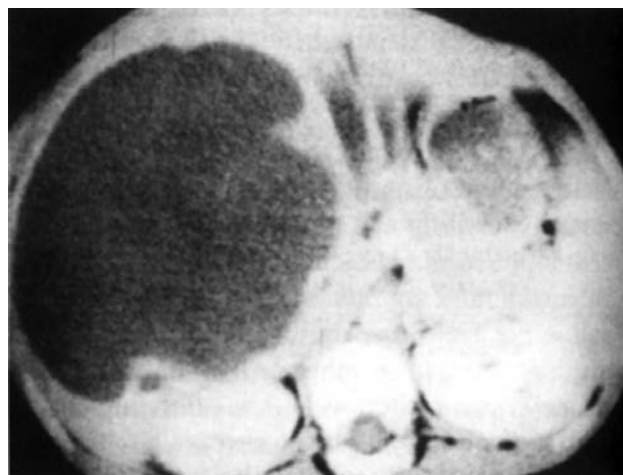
Liver abscess. CT scan (contrast enhanced) showing a large hypodense area (right lobe of liver) consistent with a solitary amebic liver abscess.
